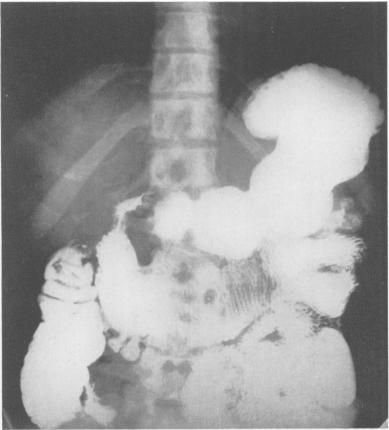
Roentgenogram after ingestion of barium meal showing dilated duodenum with large filling defect. (See Figure 2.)
